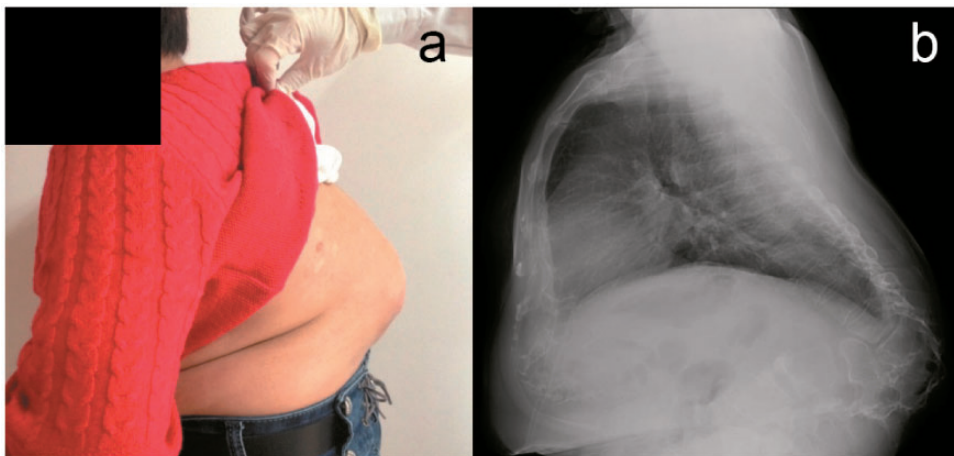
(a) Photograph and (b) X-ray film of the patient with scoliosis and kyphosis.
